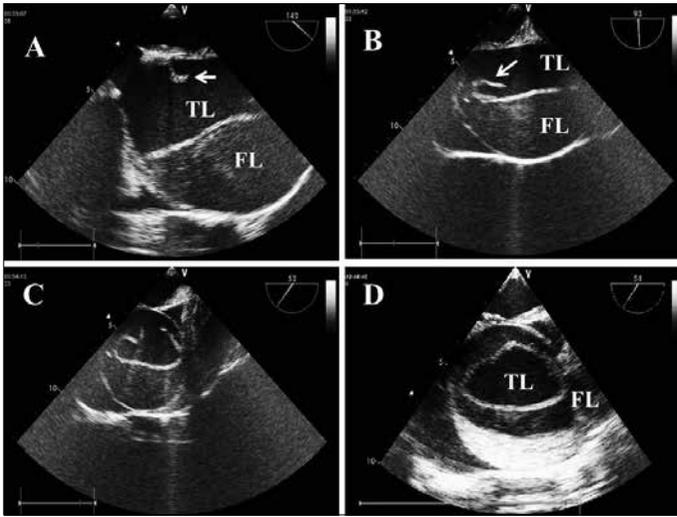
Transesophageal echocardiography demonstrates dissection flap (white arrow) in the ascending aorta. This reveals true and false lumen after dissection of the aorta in parasternal long (A, B) and short axis (C, D) views. Note posterior localization of intimal tear in parasternal short axis view at the level of sinotubular junction (C)
